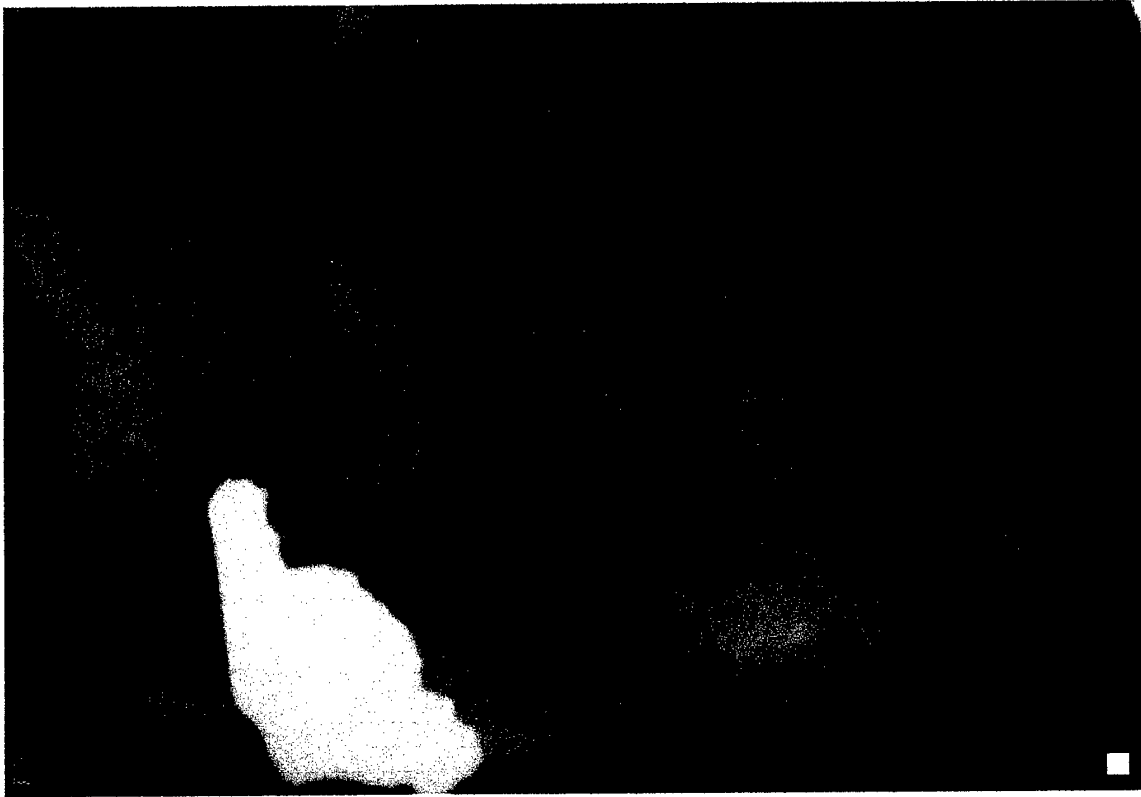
Test image with periapical lesion greater than 4.0 mm in diameter associated with root identified by digital marker.
